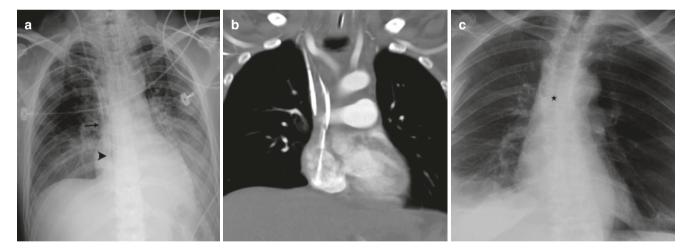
Normal tip position of central venous catheters. (a) AP radiograph shows the tip of the right internal jugular central venous catheter at the level of the bronchus intermedius (arrow) and a right peripherally inserted central catheter (PICC) with its tip 2 cm caudal to the lower margin of the bronchus intermedius (arrowhead). (b) Coronal CT image confirms the tip of the internal jugular catheter to be in mid/
